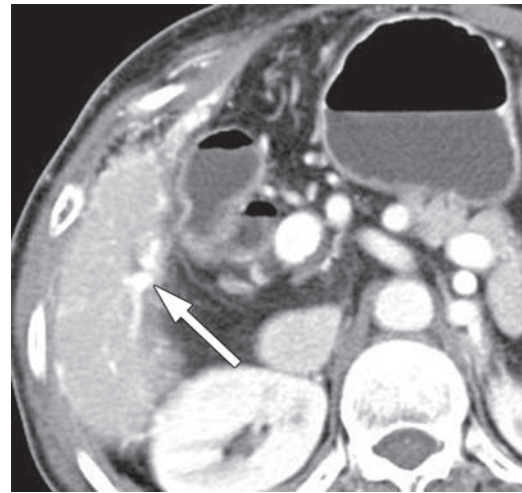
Dilated hepatic capsular vein in a 52-year-old woman who had undergone posterior segmentectomy of the liver for removal of intrahepatic stones. Contrast-enhanced CT scan shows tortuous dilatation of the hepatic capsular vein (arrow).
